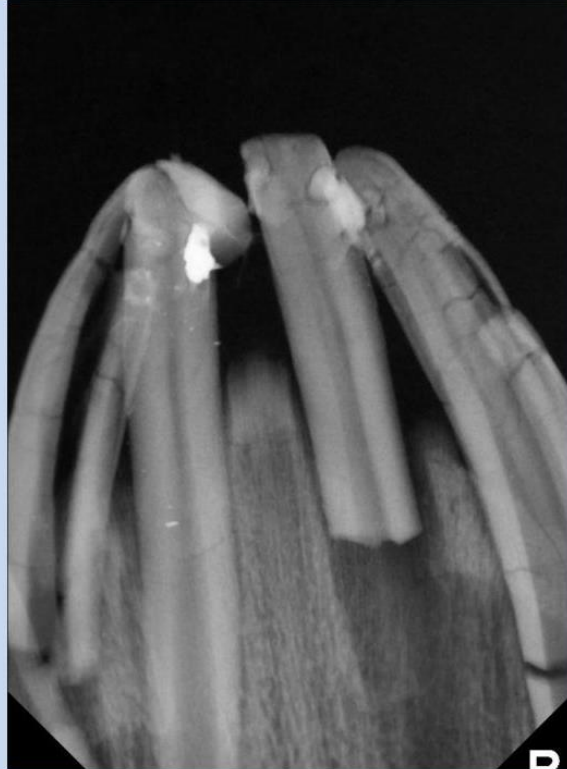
Postmortem radiograph demonstrating root fractures beneath the crestal bone.
